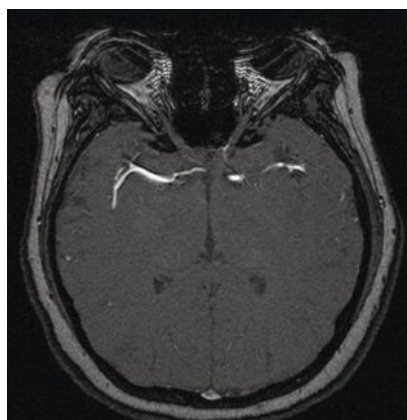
An MRI exposes a 1.4mm to 1.5mm saccular aneurysm of the anterior communicating artery.
